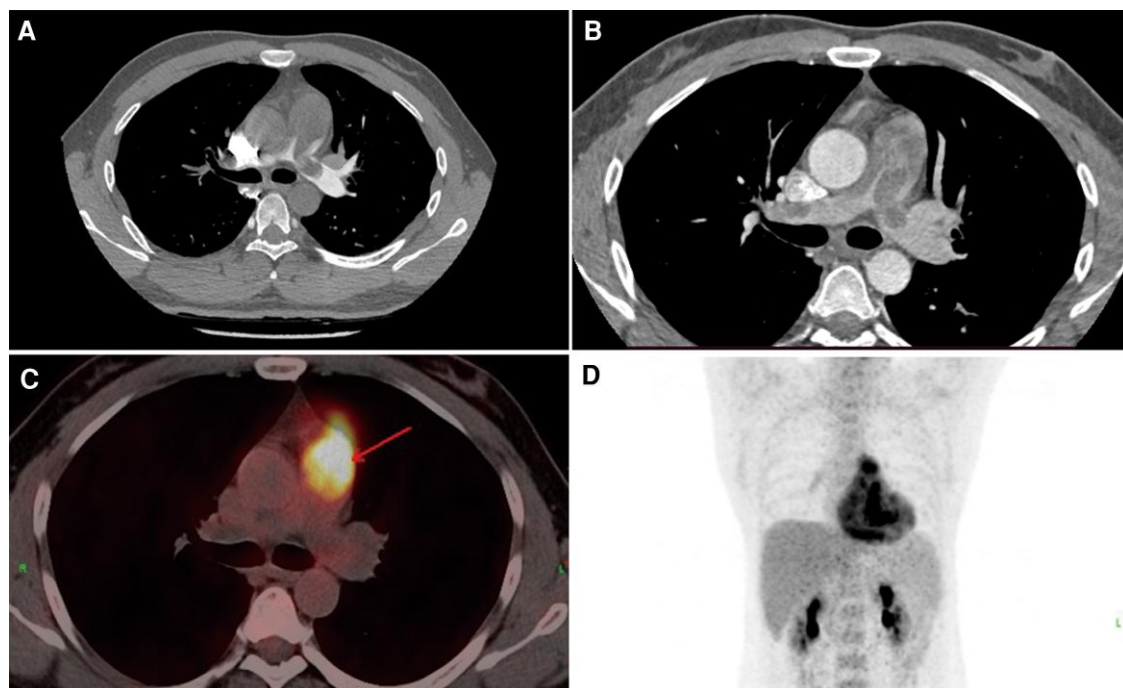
Computed tomography shows a mass in the right ventricle outflow tract, pulmonary trunk extending into bifurcation, and right pulmonary arteries (A and B); positron emission tomographic computed tomography reveals increased fluorodeoxyglucose uptake ($SUV_{max} = 15.6$) in the right ventricle outflow tract and pulmonary artery trunk (C and D).
